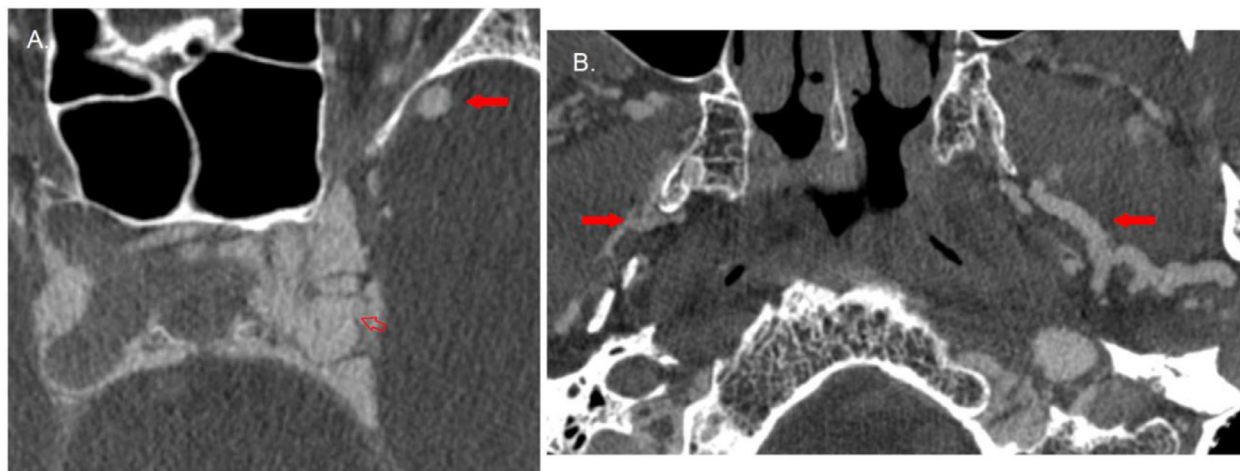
(A) Axial selective CT angiogram of the left internal carotid artery demonstrates early opacification of the left superficial middle cerebral vein (solid arrow). The presumed location of the CCF fistula is also found on this image (open arrow). (B) Axial selective CTA of the left internal carotid artery demonstrates early opacification of both pterygoid venous plexi (solid arrows).
